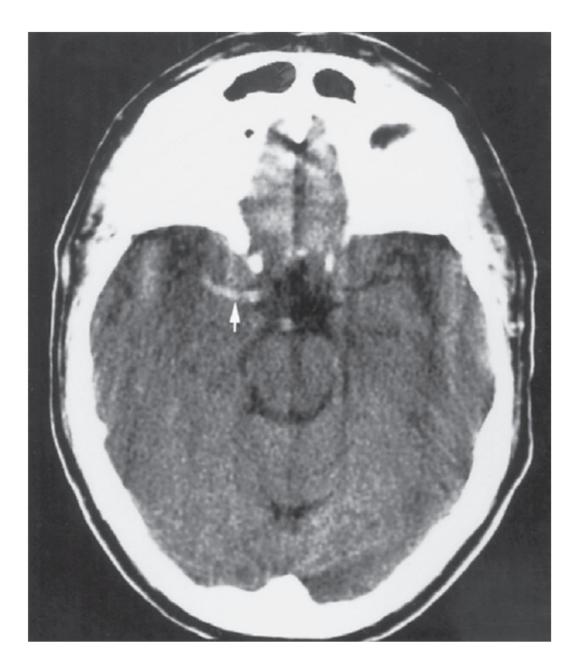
CT scan showing hyperdense MCA sign
